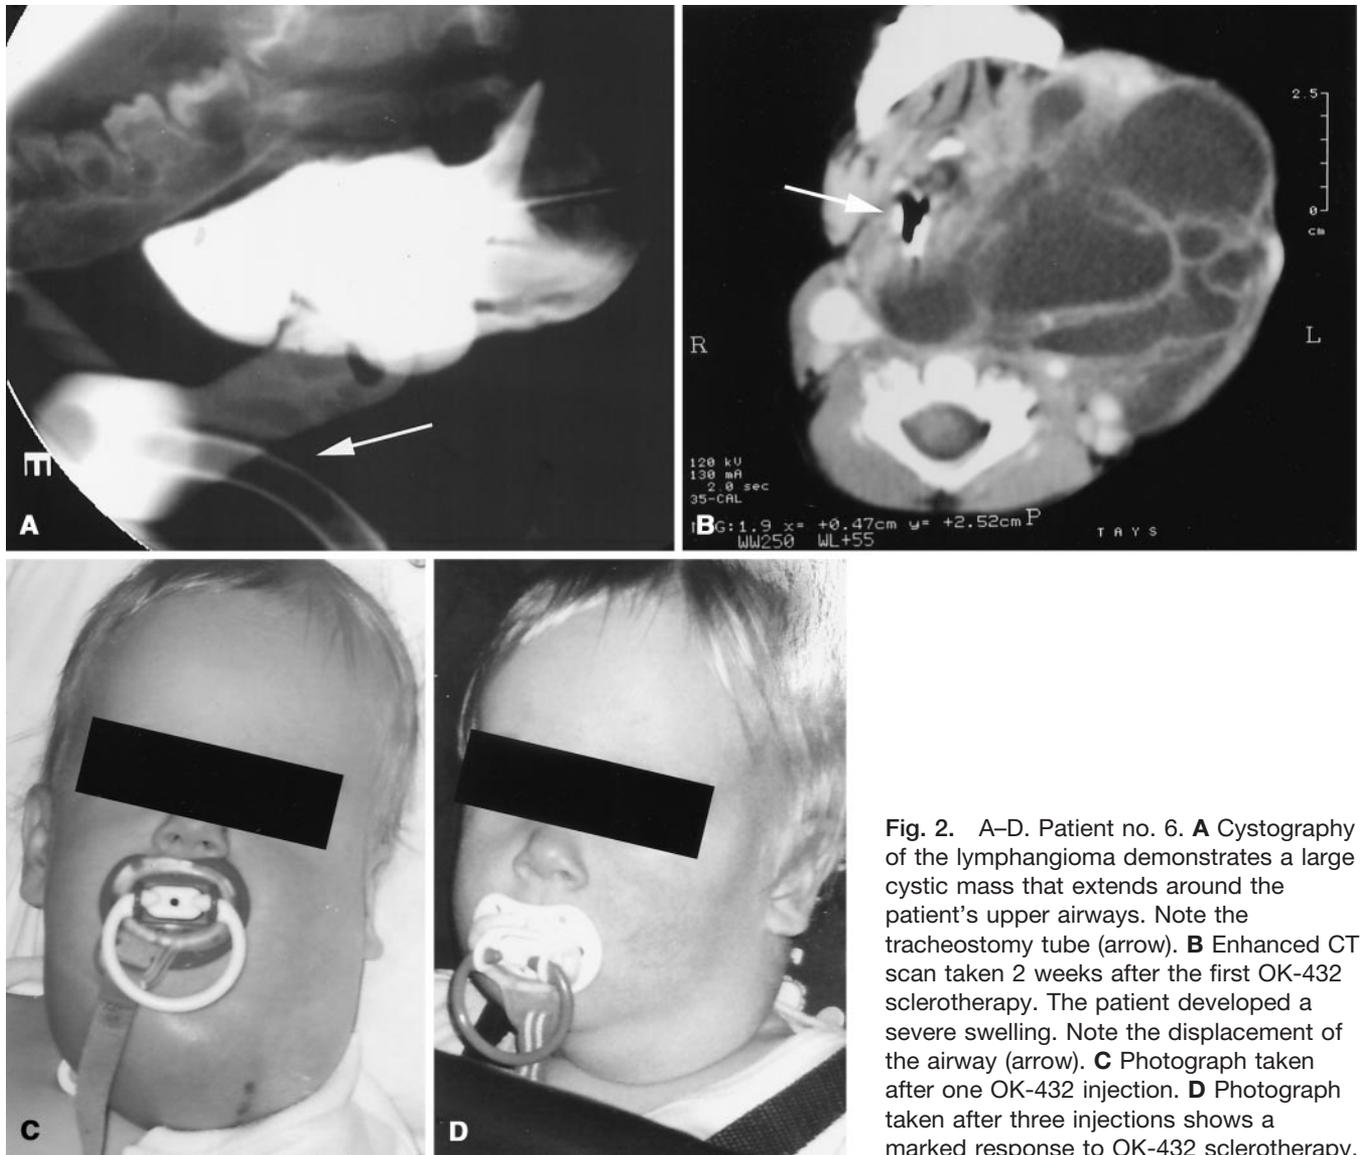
A–D. Patient no. 6. A Cystography of the lymphangioma demonstrates a large cystic mass that extends around the patient's upper airways. Note the tracheostomy tube (arrow). B Enhanced CT scan taken 2 weeks after the first OK-432 sclerotherapy. The patient developed a severe swelling. Note the displacement of the airway (arrow). C Photograph taken after one OK-432 injection. D Photograph taken after three injections shows a marked response to OK-432 sclerotherapy.
